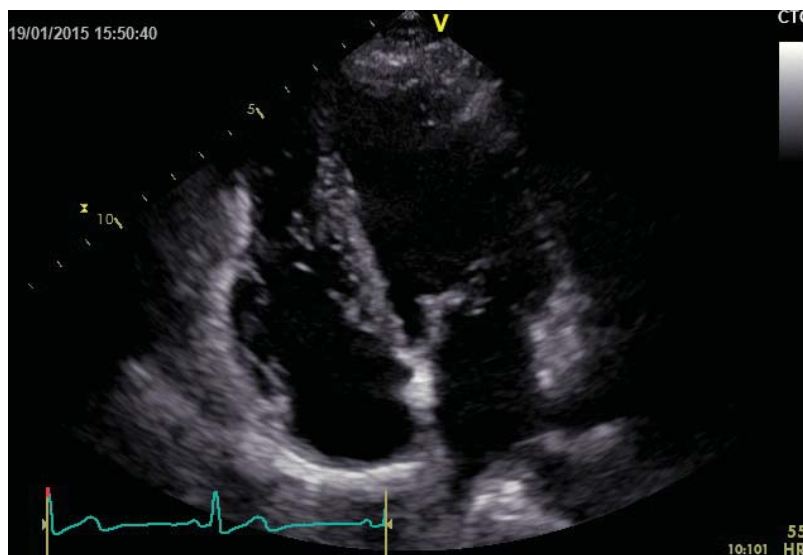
Echocardiography. Four chamber view of the heart.
